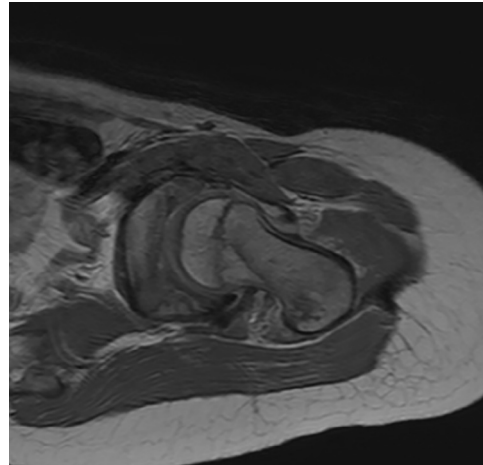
Left hip magnetic resonance imaging, oblique axial proton density sequence; curvilinear low signal intensity line abuts the physis in the proximal femoral metaphysis consistent with an occult fracture.
